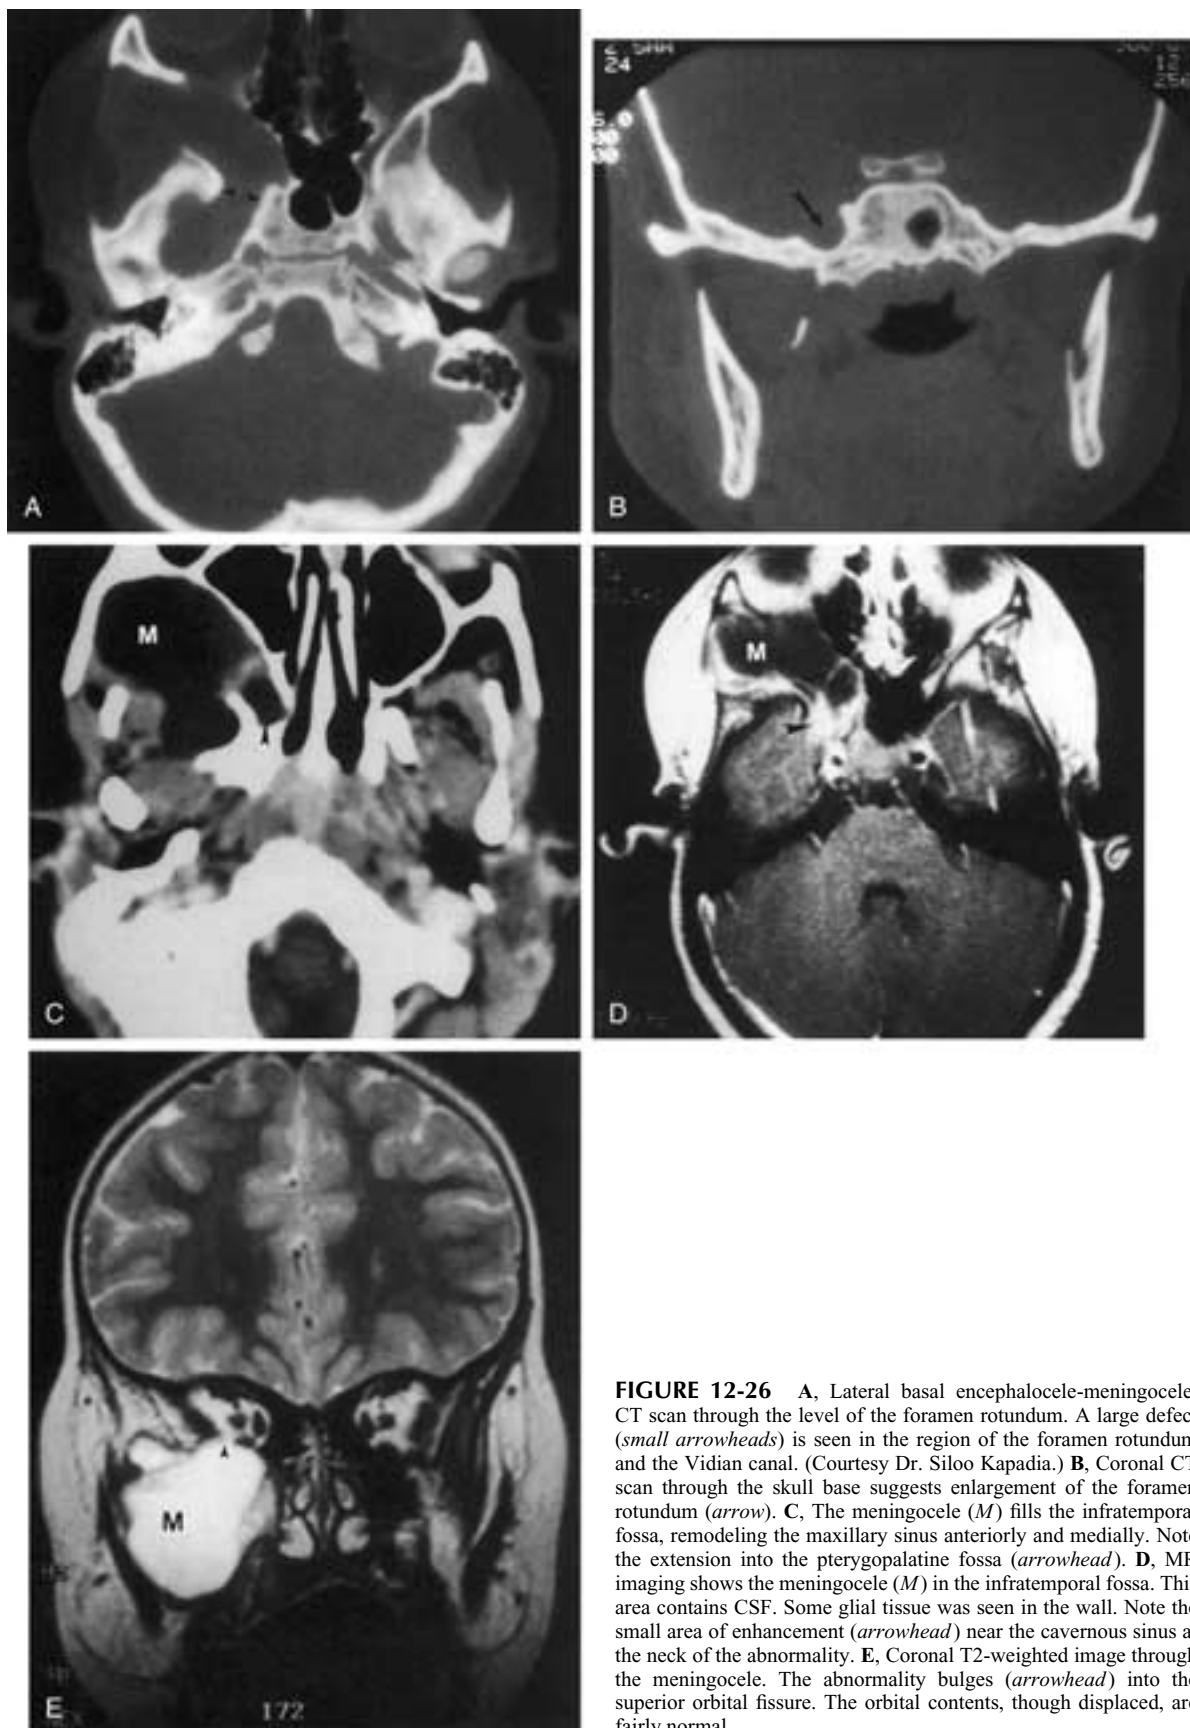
A, Lateral basal encephalocele-meningocele. CT scan through the level of the foramen rotundum. A large defect (*small arrowheads*) is seen in the region of the foramen rotundum and the Vidian canal. (Courtesy Dr. Siloo Kapadia.) B, Coronal CT scan through the skull base suggests enlargement of the foramen rotundum (*arrow*). C, The meningocele (*M*) fills the infratemporal fossa, remodeling the maxillary sinus anteriorly and medially. Note the extension into the pterygopalatine fossa (*arrowhead*). D, MR imaging shows the meningocele (*M*) in the infratemporal fossa. This area contains CSF. Some glial tissue was seen in the wall. Note the small area of enhancement (*arrowhead*) near the cavernous sinus at the neck of the abnormality. E, Coronal T2-weighted image through the meningocele. The abnormality bulges (*arrowhead*) into the superior orbital fissure. The orbital contents, though displaced, are fairly normal.
